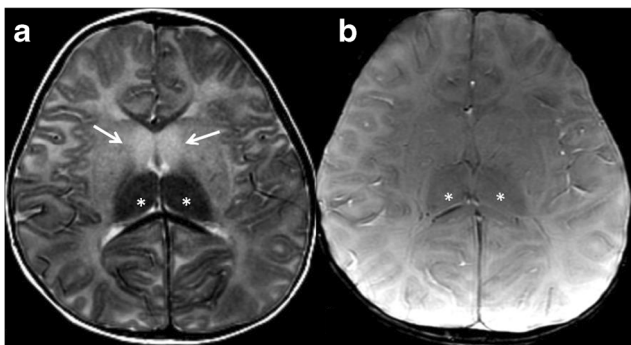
A 12-month-old male affected by Sandhoff disease (GM2 gangliosidosis). There is marked T2 hyperintensity on T2-weighted images (a) of the caudate nucleus (arrows) and marked hypointensity of the thalami (asterisks). Diffuse white matter and putaminal hyperintensity is also noted. An unusually hypointense signal is identified in the thalami on SWI (b, asterisks)
